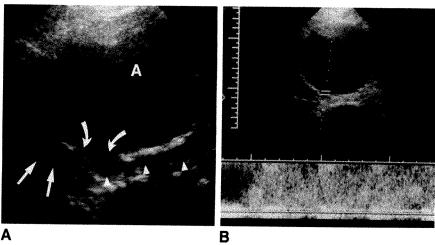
Duplex sonography showing abdominal aortic aneurysm and adjacent venous structures. A, Posterior wall disruption (curved arrows) of aneurysm (A) is visible at level of retroaortic left renal vein (arrowheads) near its confluence with inferior vena cava (straight arrows).
